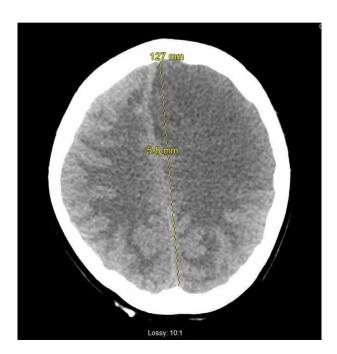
CT showed progression of acute infarct with evolution of edema and left to right midline shift.
